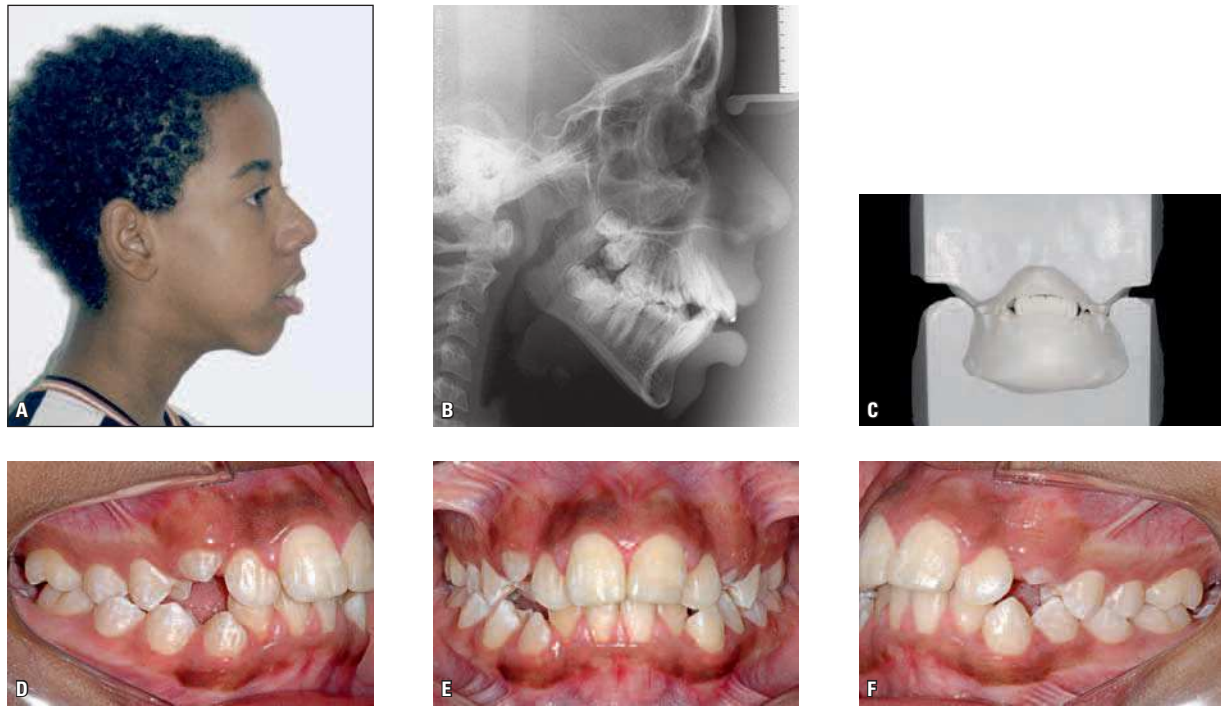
Profile photograph (A), cephalometric radiograph (B), casts (C) and intraoral photographs (D, E and F) of a patient with hyperdivergent facial pattern (SNGoGn=49°), showing excessive overbite, which can be seen more clearly in a posterior view of the plaster casts in occlusion. The lower incisors touch the palate seeking occlusal contact since there is no structure preventing its eruption.
